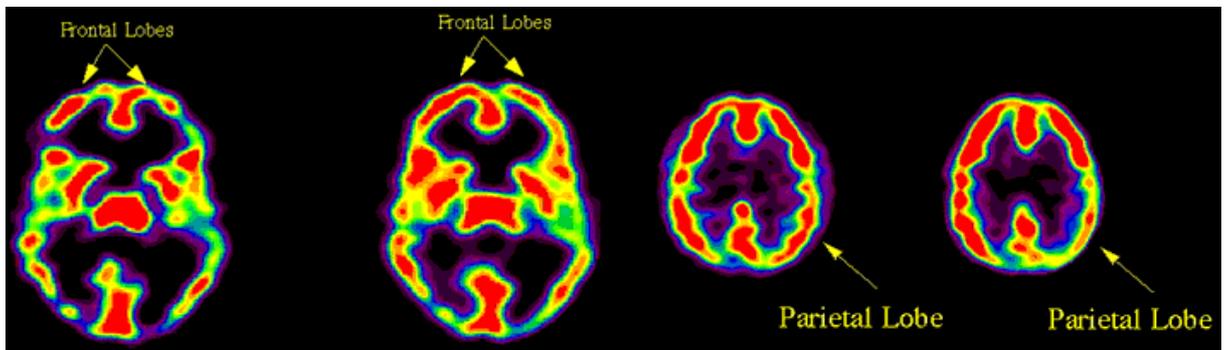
SPECT images at baseline and during meditation (from <http://www.andrewnewberg.com/research.asp>)
